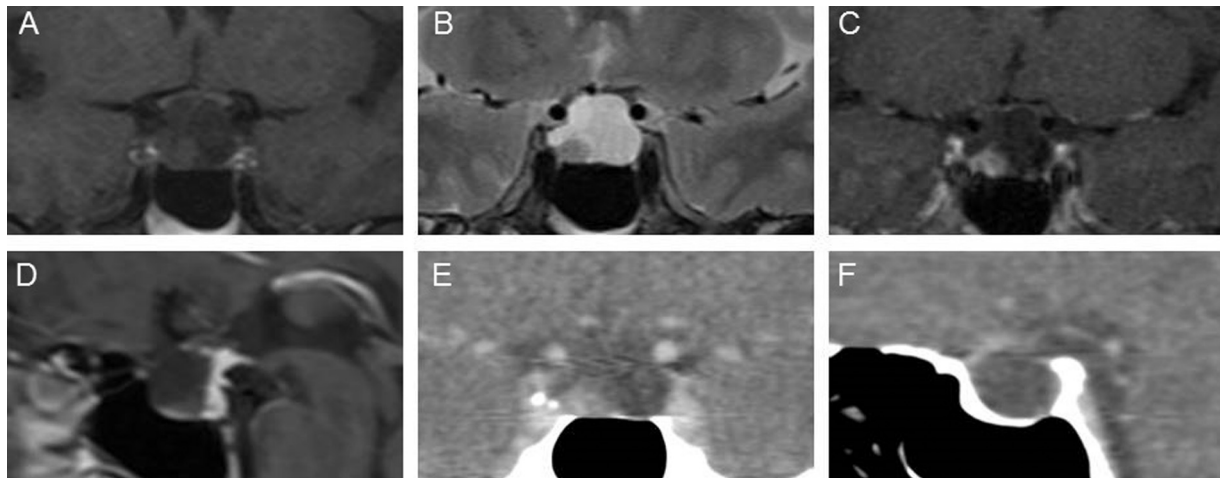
Preoperative MRI and CT images showing a cystic sellar lesion. A: Coronal T1 weighted MRI image, B: T2 weighted MRI image, C: Coronal Dynamic contrast enhanced T1 weighted MRI image, D: Sagittal dynamic contrast enhanced MRI image; E and F Coronal and sagittal contrast enhanced CT images.
